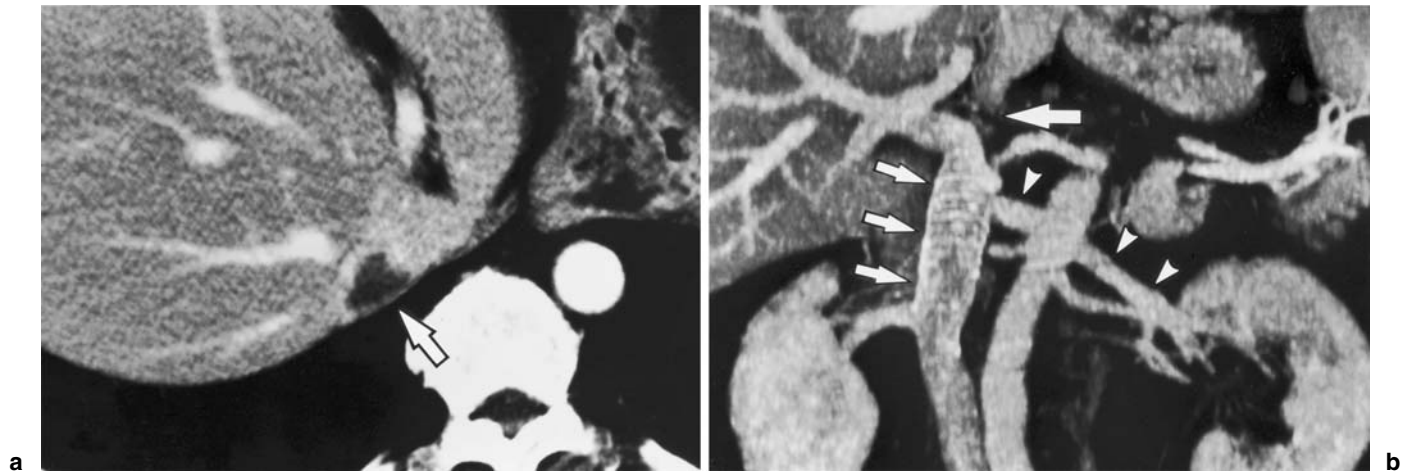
At 67 months follow-up, a enhanced CT shows the defect filled with thrombus just cranial of the downstream anastomosis of the IVC (*arrow*). b Three-dimensional CT shows both the ringed PTFE graft (*small arrows*) and the left
